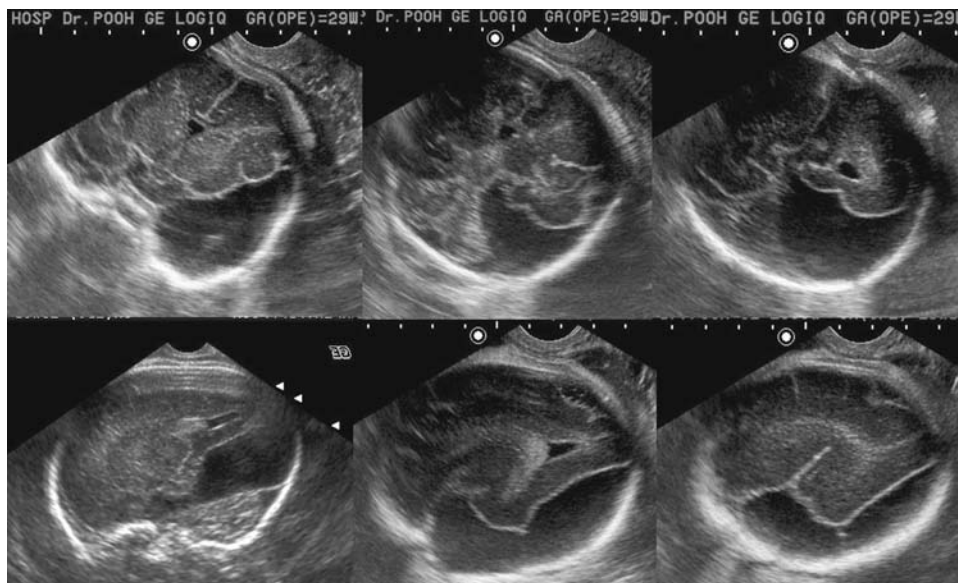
Transvaginal ultrasound images of middle fossa arachnoid cyst at 29 weeks of gestation. (Upper) Serial coronal sections. (Lower) Serial sagittal sections. Compressed adjacent cerebrum is demonstrated.
